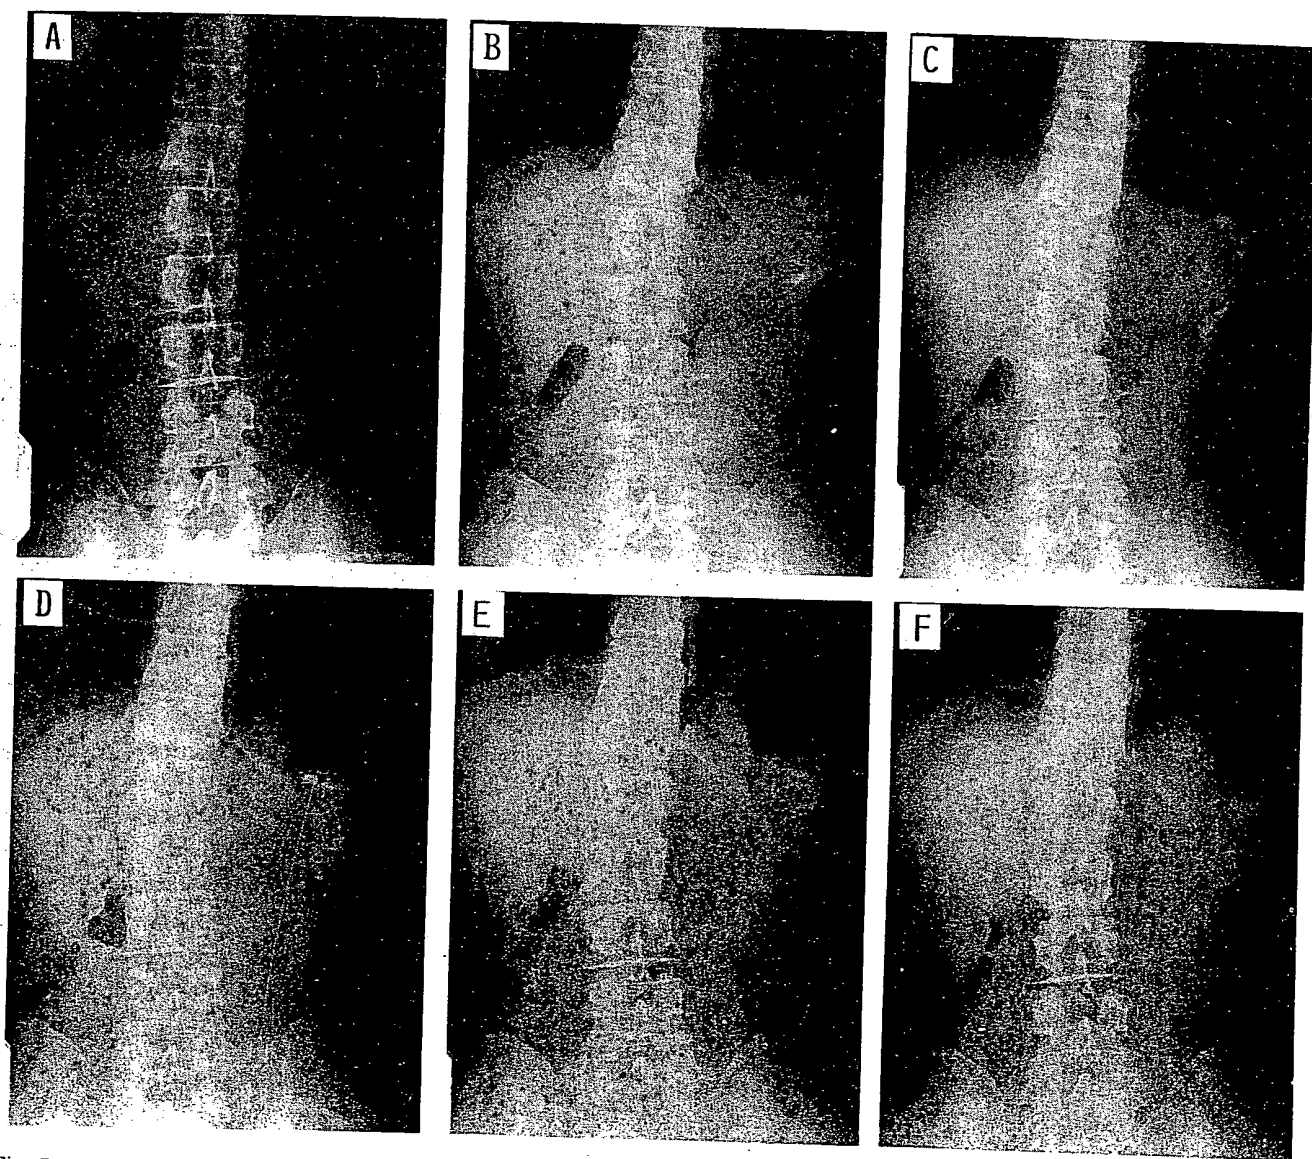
X-ray photographs of tranilast microballoons (density= $0.92 \text{ g/cm}^3$ ) containing barium sulfate in the gastrointestinal tract at (A) 0 min, (B) 15 min, (C) 30 min, (D) 60 min, (E) 90 min, and (F) 150 min after dosing in the fed state.
